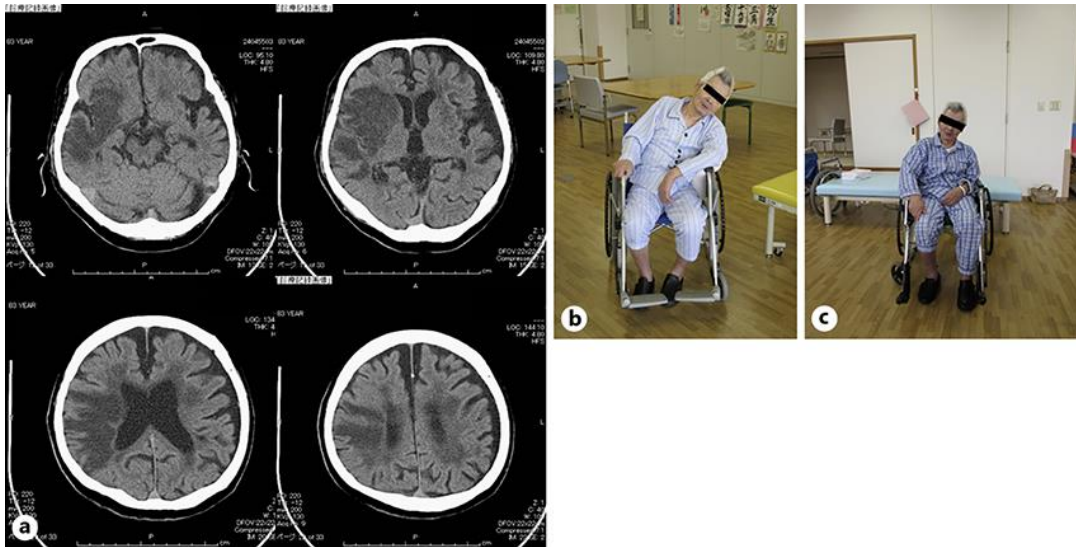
a CT of the brain demonstrating broad infarction of the right middle cerebral artery territory. b Sitting posture before tDCS intervention. c Sitting posture after tDCS intervention.
